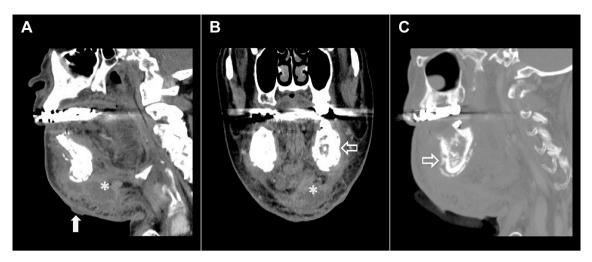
Contrast-enhanced computed tomography (A, sagittal; B, coronal-reformatted) images show extensive subcutaneous swelling, abscess (asterisk) in the submandibular space and a fistula (arrow) noted. The airway is patent. (C) Bone window image revealing periosteal reaction, osteolytic and osteoblastic changes, and intramedullary sequestra within the mandibular body (open arrow). The computed tomography findings are consistent with osteonecrosis of the jaw.
